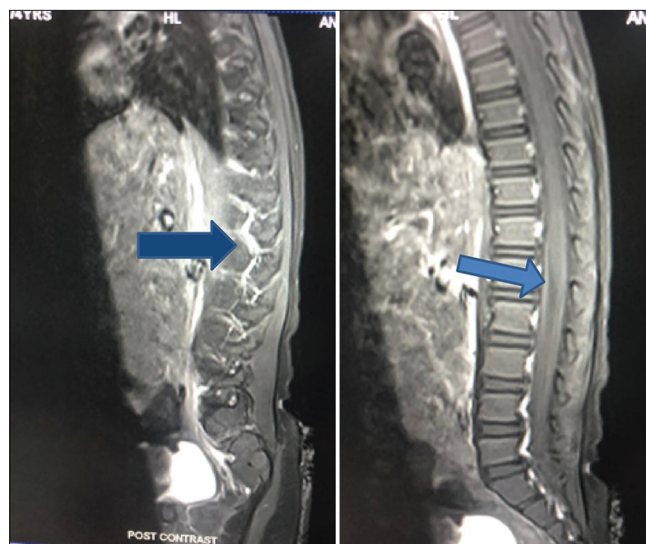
MRI spine showing abnormal thickening and enhancement of spinal nerve roots
